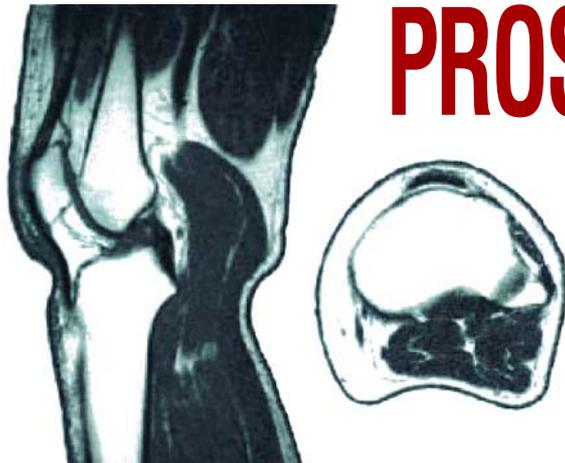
Mid-sagittal plane and MTP-2.5 cm transverse MRI cross sections of the transtibial amputee in Figure 1c.
